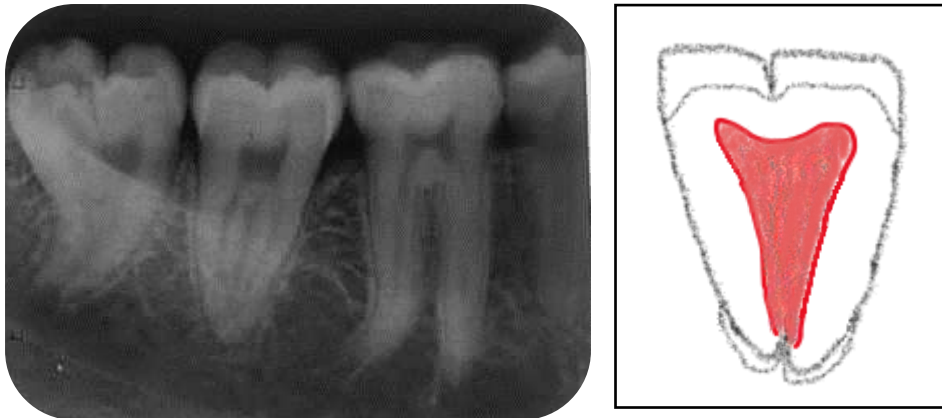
Intra-oral radiograph in relation to 48 region showing gemination.
